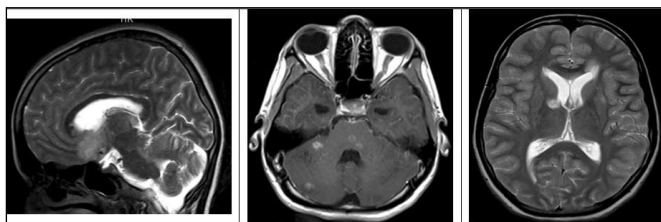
MRI brain: multifocal acute infarctions with multiple small tuberculomas within the brain parenchyma involving both supra and infratentorial compartments. These are associated with diffuse nodular enlargement more marked in basal region.
